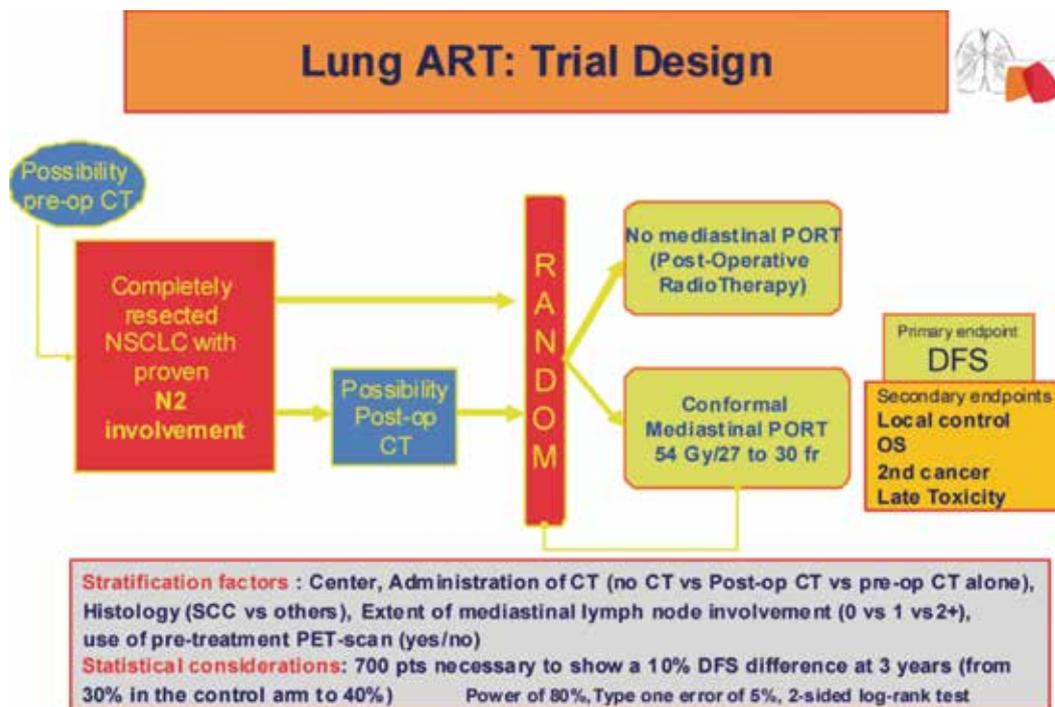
Lung adjuvant radiotherapy trial (ART) design. CT, chemotherapy; DFS, disease-free survival; NSCLC: non-small cell lung cancer; PET, positron emission tomography; PORT, postoperative radiation therapy; post-op, postoperative; pre-op, preoperative; SCC, squamous cell carcinoma.
